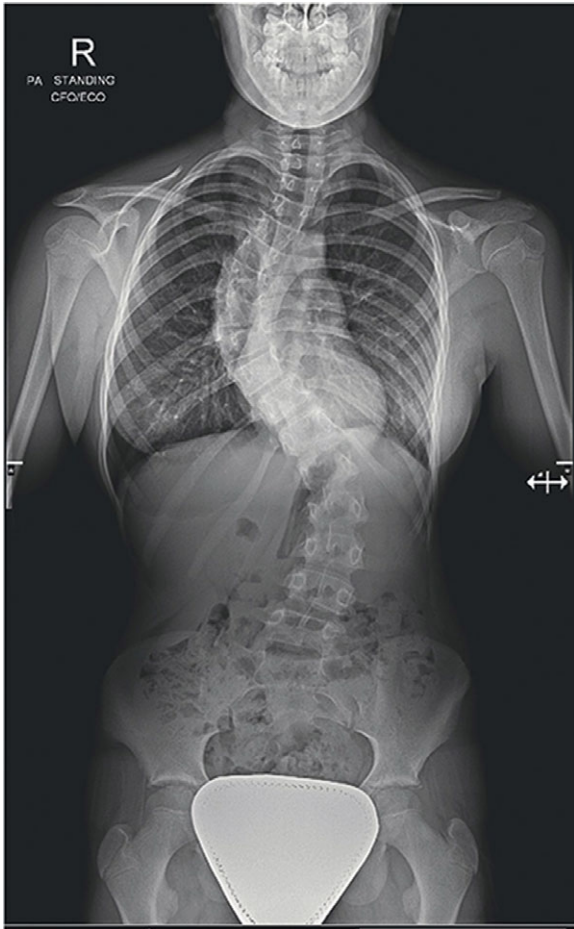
AP radiograph spine
